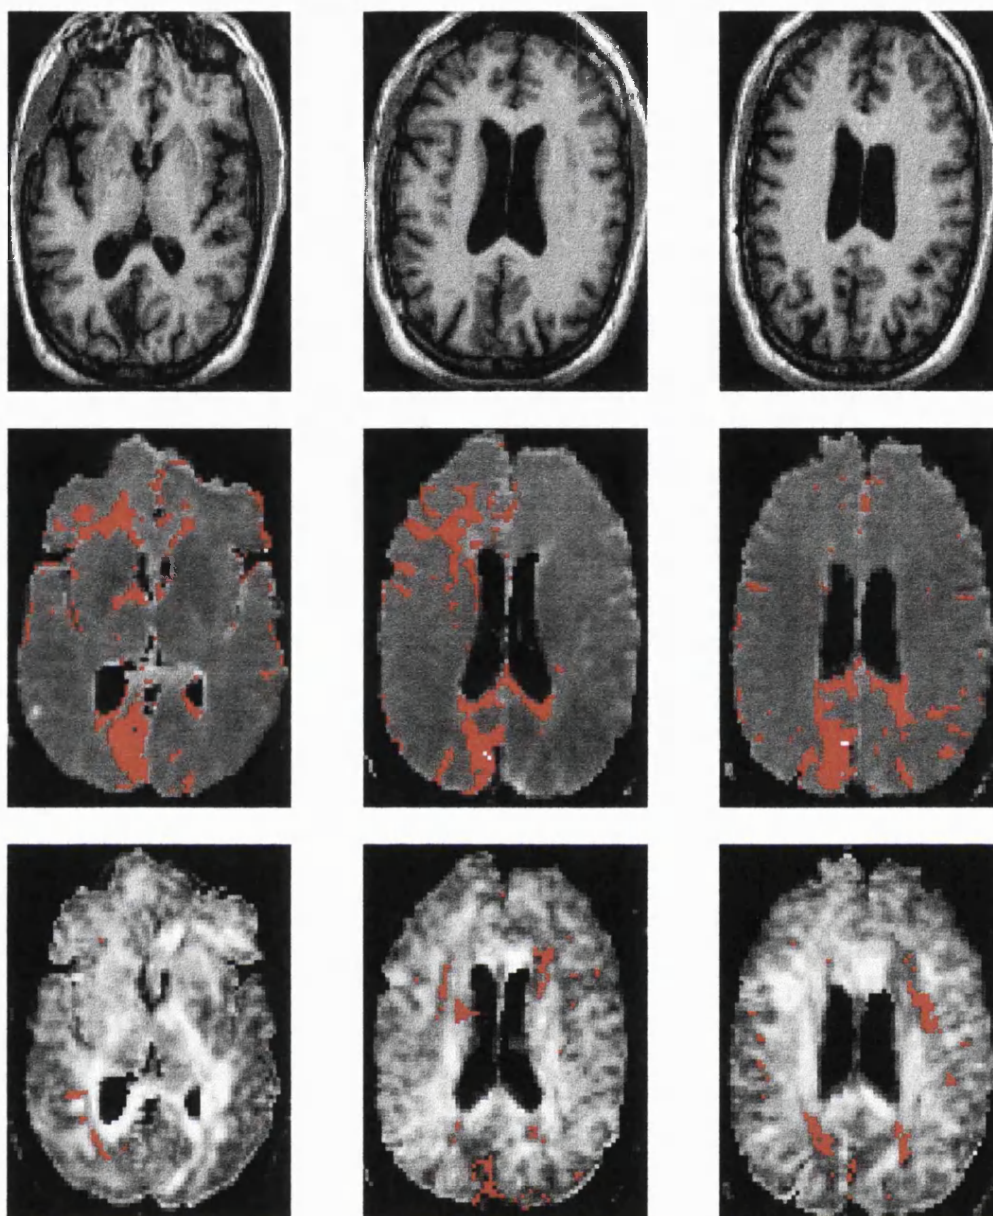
Diffusion tensor imaging and standard T1 weighted images in traumatic brain damage causing right quadrant anopia, impaired memory and epilepsy. T1-weighted images (top row) show brain atrophy. Maps of the mean diffusivity show widespread increase of the magnitude of diffusion (pixels with significantly *increased* mean diffusivity are shown in red). Maps of the anisotropy of diffusion (bottom row) show a decrease of the directionality of diffusion in myelinated structures including the right optic radiation (bottom left) and the forceps major of the corpus callosum (bottom right), (pixels with significantly *decreased* anisotropy are shown in red).
